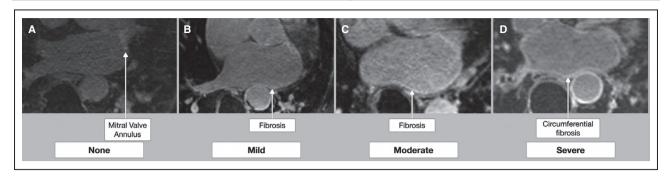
Representative left atrial cardiac magnetic resonance imaging showing various degrees of late gadolinium enhancement suggestive of a normal left atrium (A), focal area of fibrosis on the posterior wall of the left atrium (B), diffuse posterior wall fibrosis (C), and circumferential fibrosis (D).
